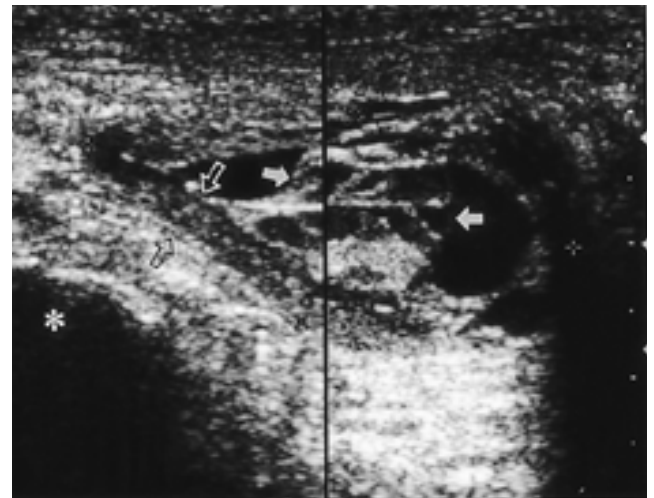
Ultrasound (US) of 78-year-old woman with a hard and movable mass on her left buttock for 3 months shows a cystic mass, located superficially to ischial tuberosity (asterisk), with multiple septa (solid arrows), low echoic cystic wall (open arrows), and mixed echogenicity of fluid (compartmentalization).
